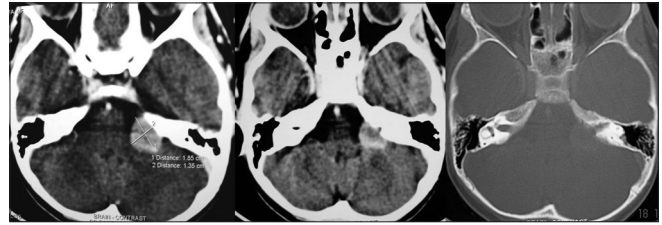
CT scan brain plain with contrast shows left extra-axial contrast enhancing lesion
